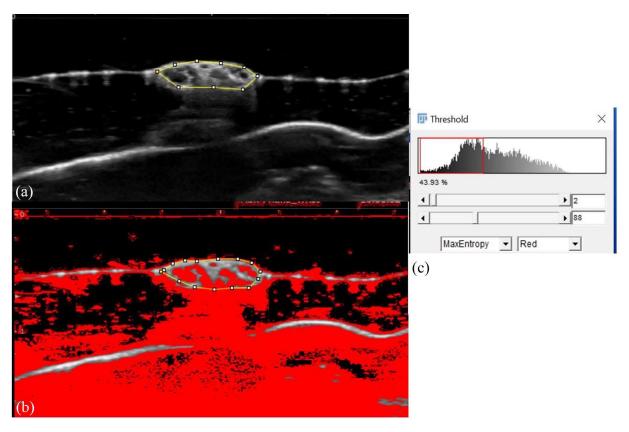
Quantitative assessment of nerve echo intensity: (a) cross-sectional ultrasound image of the nerve with region of interest manually selected and (b) Gaussian filter was used to enhance contrast between hypoechoic and hyperechoic areas within the nerve. Red area indicates area below threshold. (c) The threshold can be set manually by adjusting the sliding bar.
